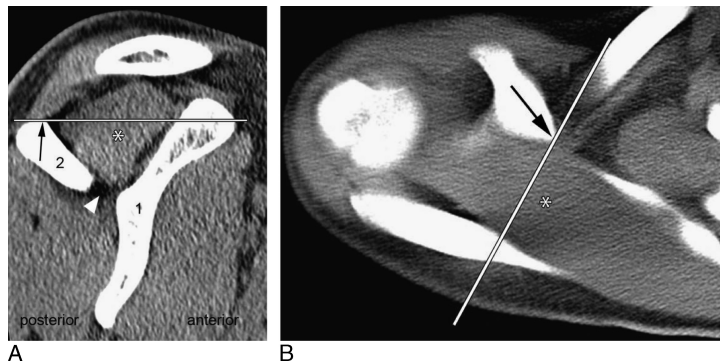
Reformatted parasagittal (A) and axial (B) CT images of the right shoulder of a 20-year-old male patient. In the parasagittal plane (A), grading of fatty infiltration of the supraspinatus muscle (*) was performed on the most lateral image on which there was no bony bridge (arrowhead) seen between the scapular body (1) and the scapular spine (2). In the axial plane (B), the rating was performed on the image touching the superior contour of the scapular spine (arrow on A and B) in the parasagittal image used for rating in the parasagittal plane (white bars). The supraspinatus muscle of this patient was rated zero on Goutallier in both planes by all readers.
